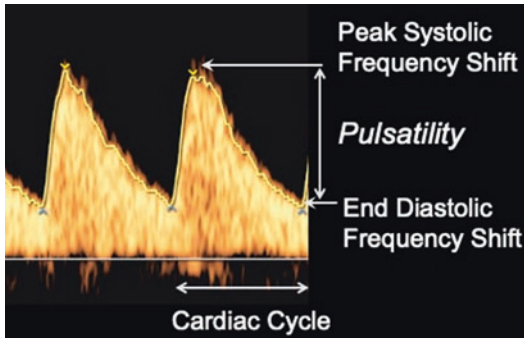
Pulsatility of an arterial velocity waveform. The example shows Doppler waveforms from the umbilical arteries. Vertical axis represents the velocity magnitude. Horizontal axis represents the time
